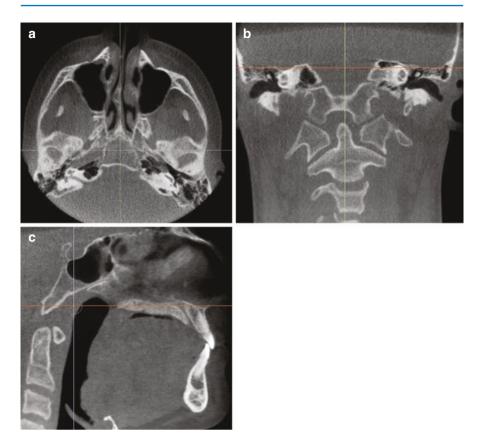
Prior to evaluating a CBCT volume, anatomic orientation is necessary to increase efficiency and efficacy. In the axial view (a), orientation of the coronal plane (blue line) with relatively consistent anatomy, such as the foramen ovale, as shown here, will orient the skull anatomically in coronal plane. In the coronal view (b), orientation of the axial plane (red line) with, for example, the tegmen tympani (roof of the middle ear cavity) will orient the skull anatomically mediolaterally in the axial plane. In the sagittal view (c), orientation of the axial plane (red line) with the hard palate (from the anterior nasal spine to the posterior nasal spine) or with the Frankfort plane will orient the skull anatomically mediolaterally in the axial plane
